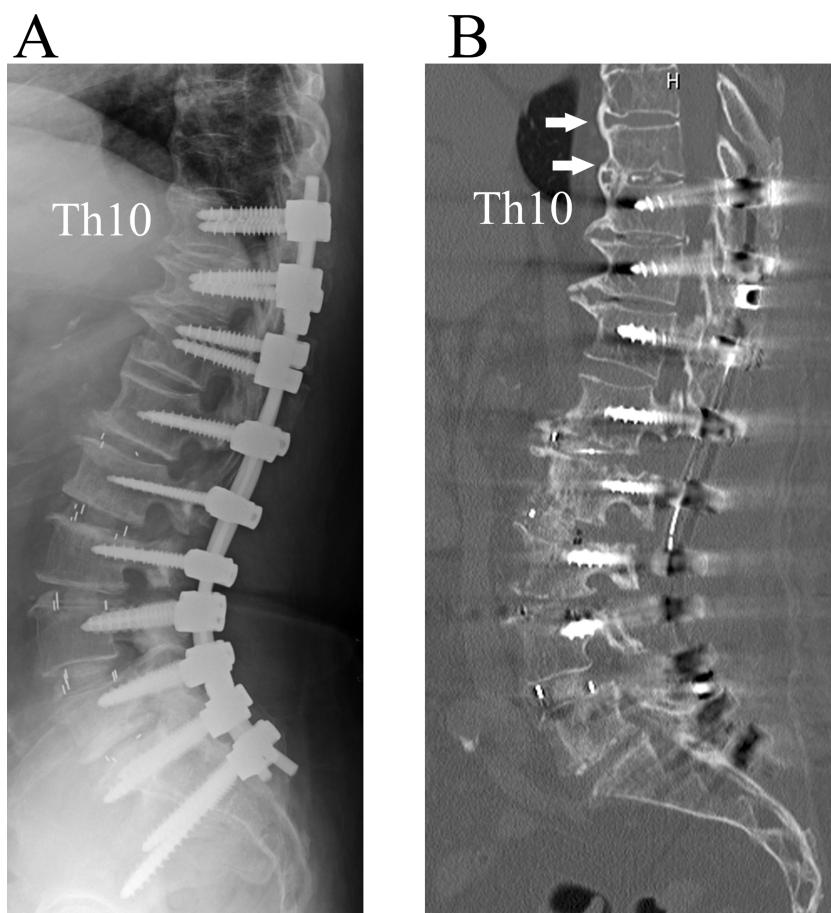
A, Postoperative lateral radiograph demonstrating increased lumbar lordosis and posterior instrumentation from Th10 to the sacrum. B, Postoperative sagittal reconstructed computed tomographic scan revealing confluent hyperostosis in the anterior longitudinal ligaments (arrows) above the uppermost instrumented vertebra (Th10).
